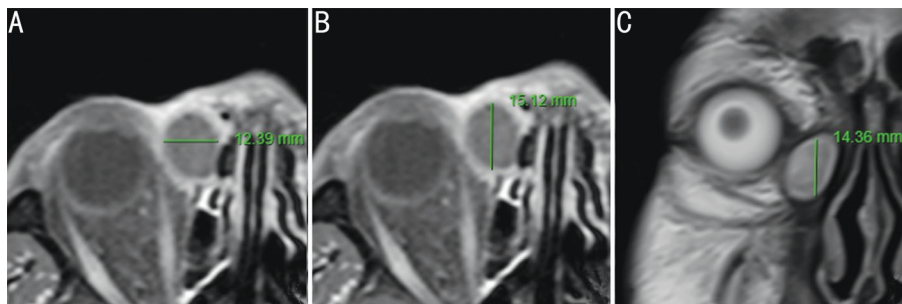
Maximum dacryocyst diameters in three planes being measured in MRI images A, B: Horizontal length and sagittal length were measured in sagittal planes; C: Vertical length was measured in vertical plane. MRI: Magnetic resonance imaging.
